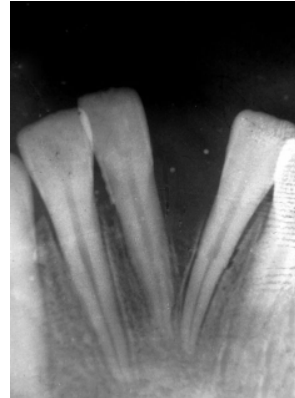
Periapical radiograph showing loss of interproximal bone.
